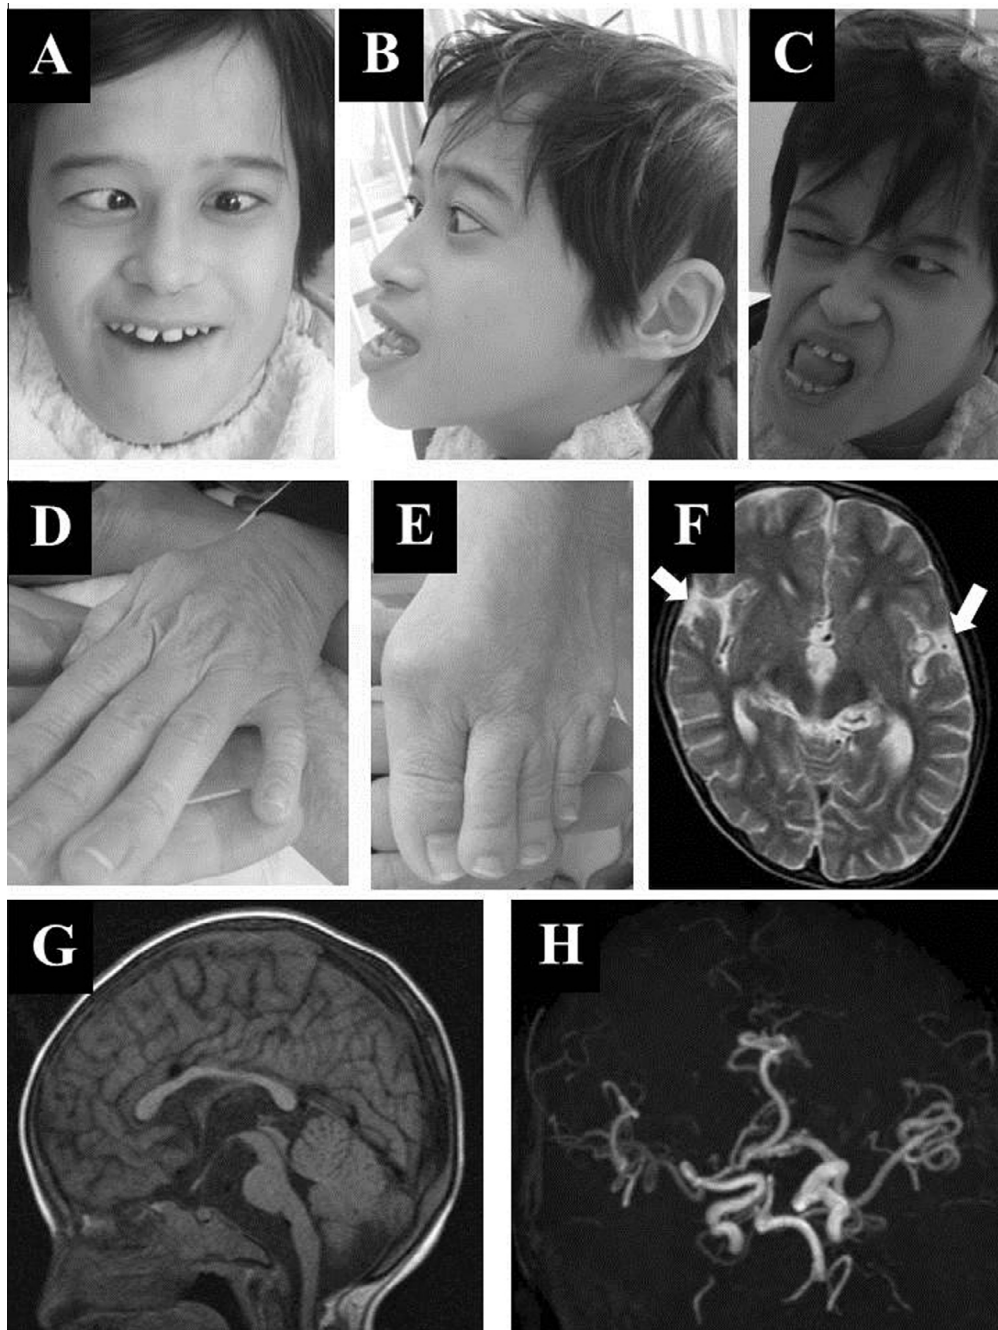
(A) and (B) Frontal and lateral views of the patient's facial dysmorphism. (C) Grimacing. (D) The patient's left hand and (E) foot show cutis laxa. (F) Axial T2-weighted brain MRI showing mild cortical atrophy (solid arrows). (G) Sagittal T1-weighted brain MRI showing the thin corpus callosum, and (H) magnetic resonance angiography showing marked kinking and tortuosity of the brain vessels. (We got written consent form for usage of pictures of the patient from parents).
